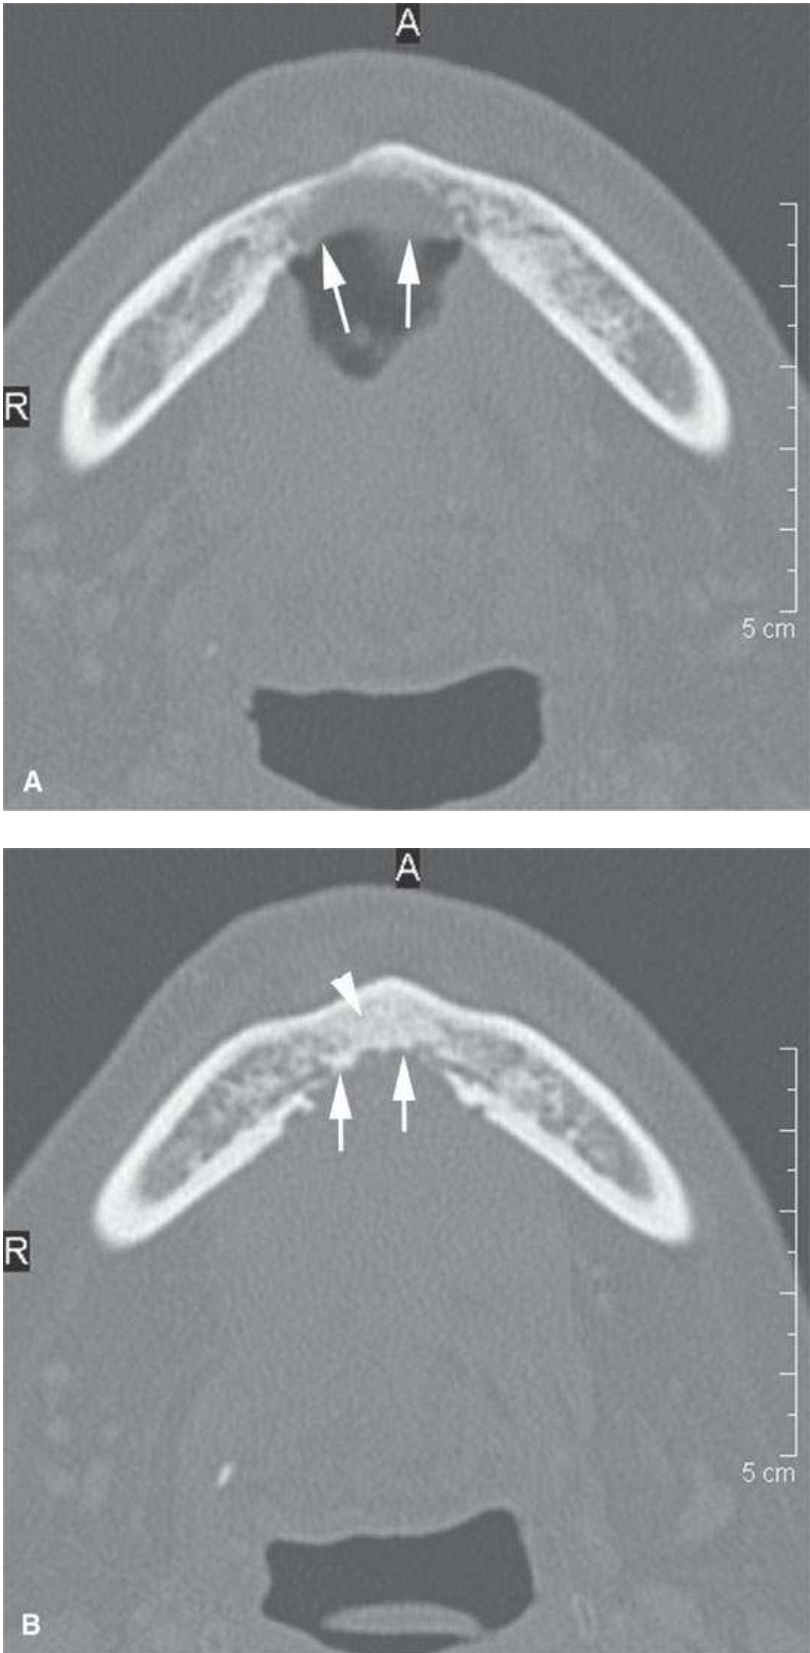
Computed tomography study showing mandible lingual plate destruction by squamous cell carcinoma (*arrows in A*) healing at the cortical margins (*arrow*) and within the marrow space (*arrowhead*) in (bB).
